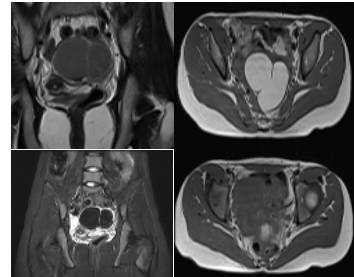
MRI showing T2dark spot sign and Shading phenomenon suggestive of chronic hemorrhage-endometrioma.
